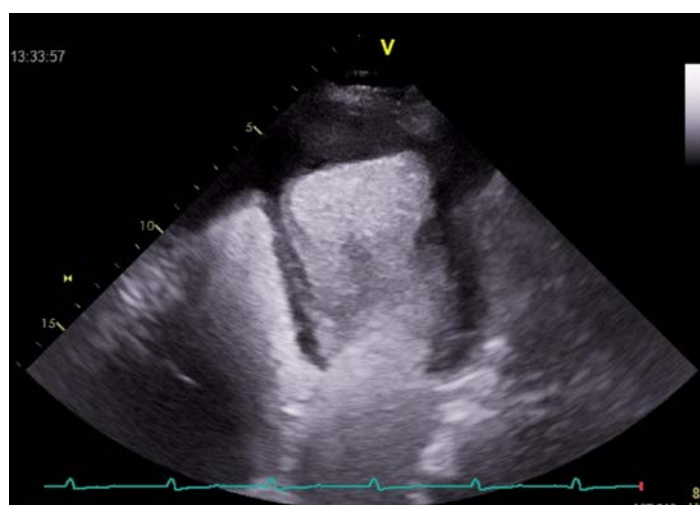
Contrast echocardiography shows large parietal thrombosis which is shown as avascular (black) formation at the left ventricle apex on transthoracic four chamber view.
